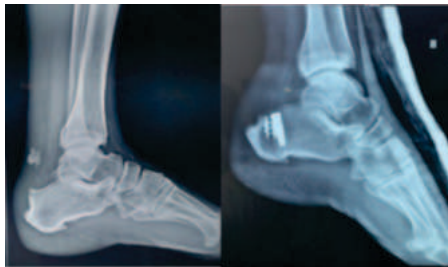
Pre-operative and post-operative x-ray images
